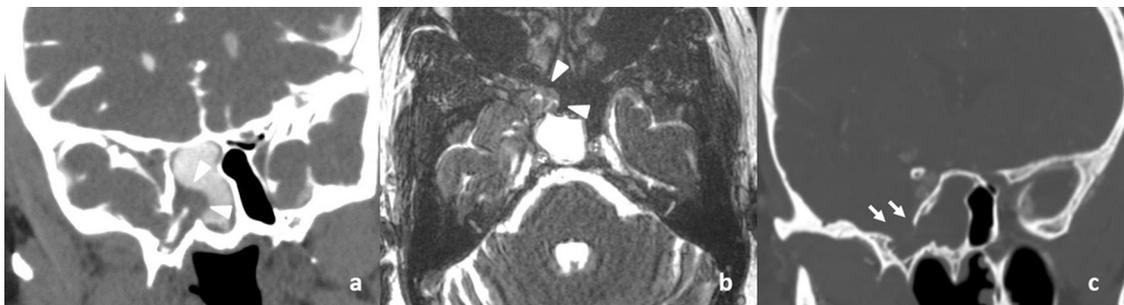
Thirty-six-year-old woman with watery nasal discharge on right side: a–b: CT and MR cisternography images show herniation of right medial temporal lobe into the sphenoid sinus with leakage of CSF into sphenoid sinus i.e., Sphenoidal encephalocele (arrowheads); c: coronal CT image of sphenoid sinus in bone window shows erosion of the lateral wall of sphenoid sinus (arrows).
